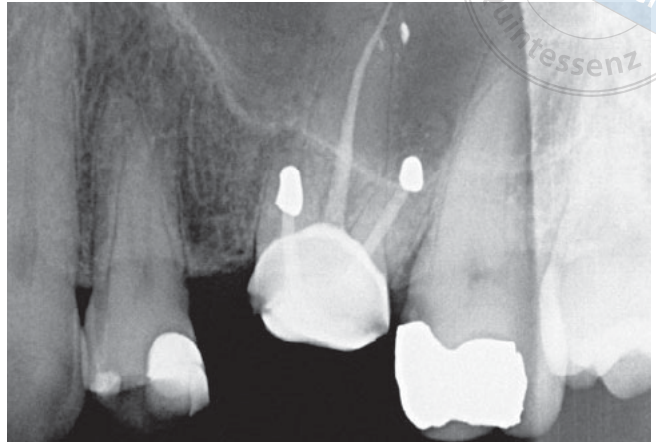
Radiographic image to check the approximal marginal adaptation of DME to the dentin. Note the secondary caries lesion in the second molar.
